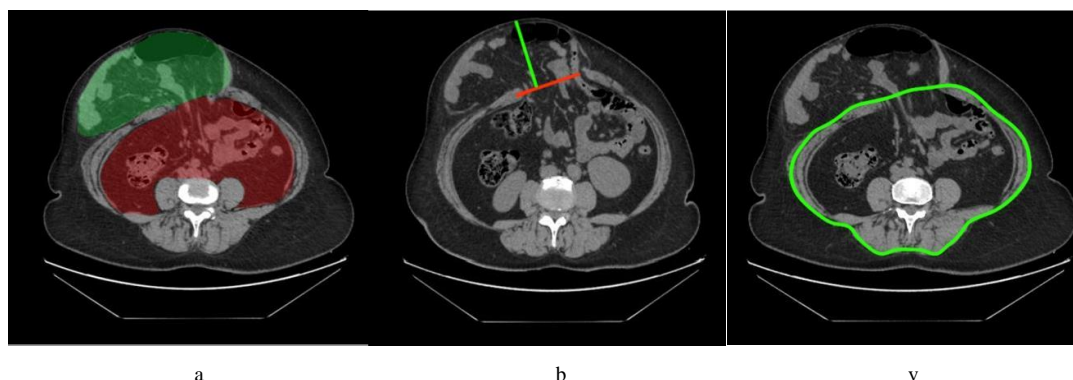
Scheme for measuring CT dimensions: a – volumes of the hernial sac and abdominal cavity, b - the size of the hernial orifice and hernial bag, V - circles abdominal walls
